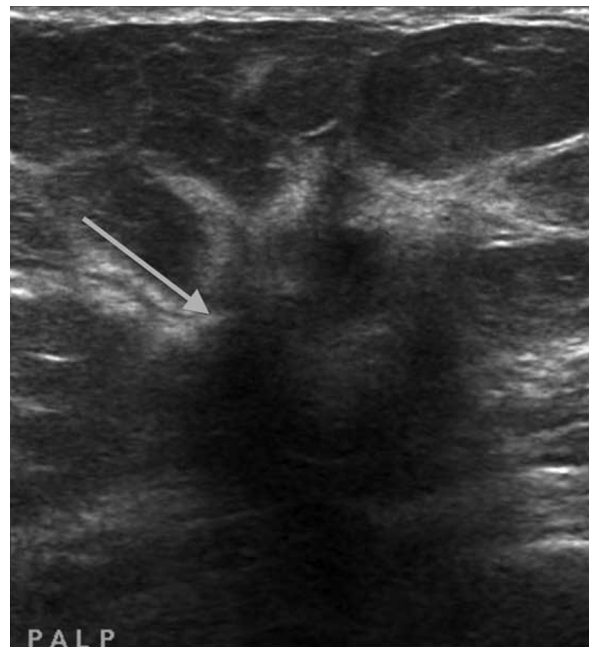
79-year-old woman with brachial plexus tumor. Right breast carcinoma. Antiradial ultrasound shows a typical irregular hypoechoic mass (arrow) with some angulated margins at 3 o'clock in the right breast.
